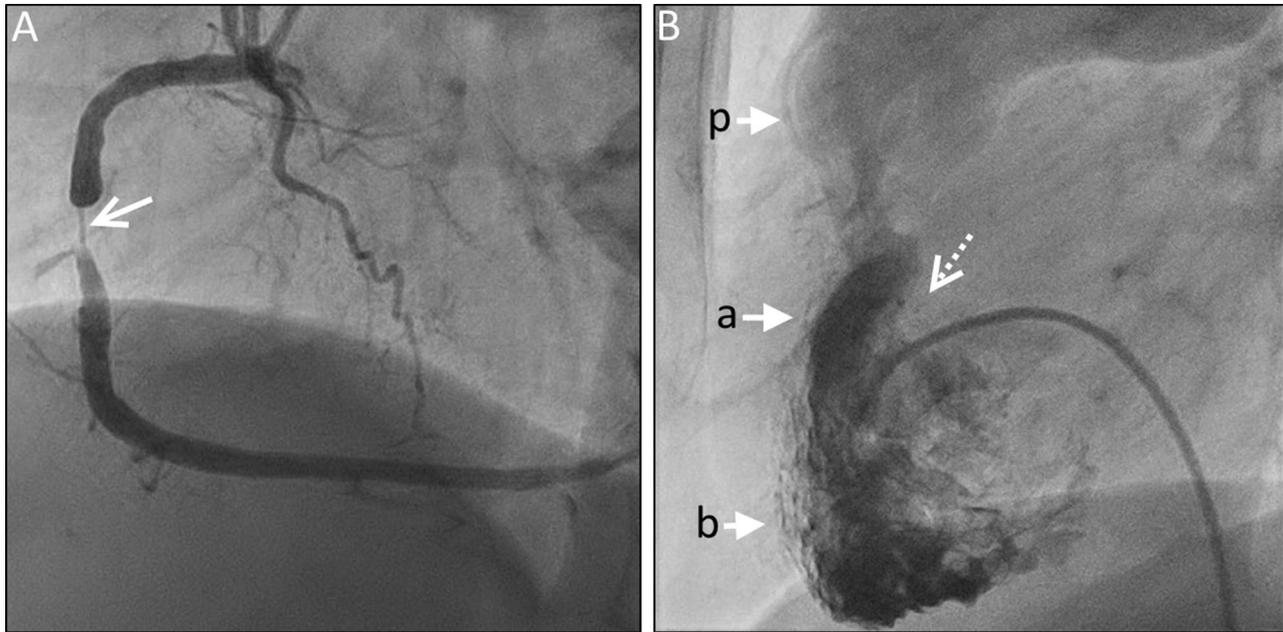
Coronary angiogram done after two days of stress/rest SPECT MPI (A) showing a significant (95%) stenosis in the proximal right coronary artery (arrow). The RV catheterization study (B) shows an anomalous muscle band (dotted arrow) dividing the RV cavity into a proximal high pressure chamber (a) and a distal low pressure chamber (b) leading to the diagnosis of double chambered right ventricle (DCRV). The proximal chamber systolic pressure was of 160 mm Hg and distal chamber systolic pressure of 40 mm Hg with gradient of 120 mm Hg; p-pulmonary valve.
